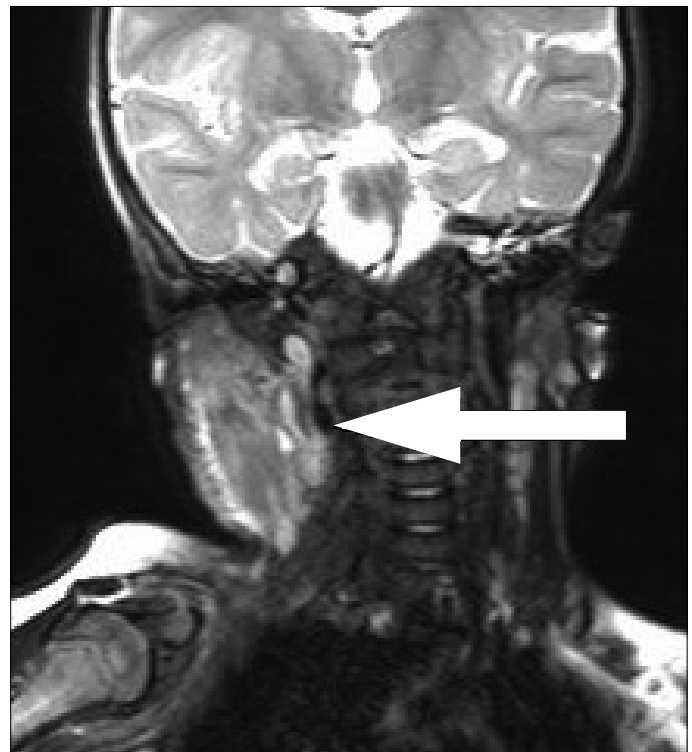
In the contrast-enhanced computerized neck MRI examination, inflammation and parapharyngeal abscess image extending from the right localization towards the deep fascial planes, showing liquefaction necrosis and heterogeneous contrast involvement in the central cut (Patient number 7)
